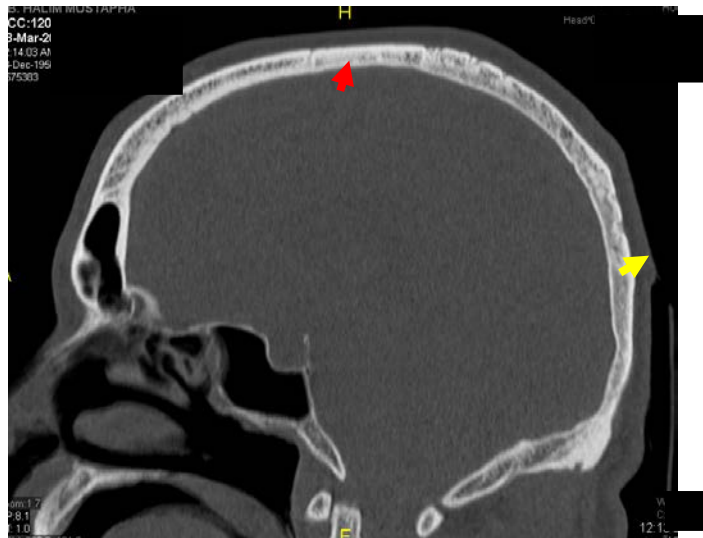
Mid sagittal image of CT brain in bone window setting showing coronal suture and lambda suture. Red arrow head line showing coronal suture and yellow arrow head line showing lamdoid suture.
